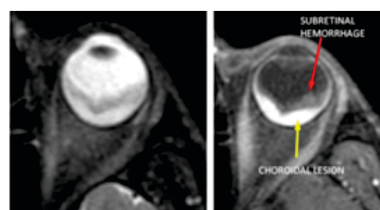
MRI showing well defined homogenously enhancing lesion in retinochoroidal layer of left globe along the posterior aspect.
